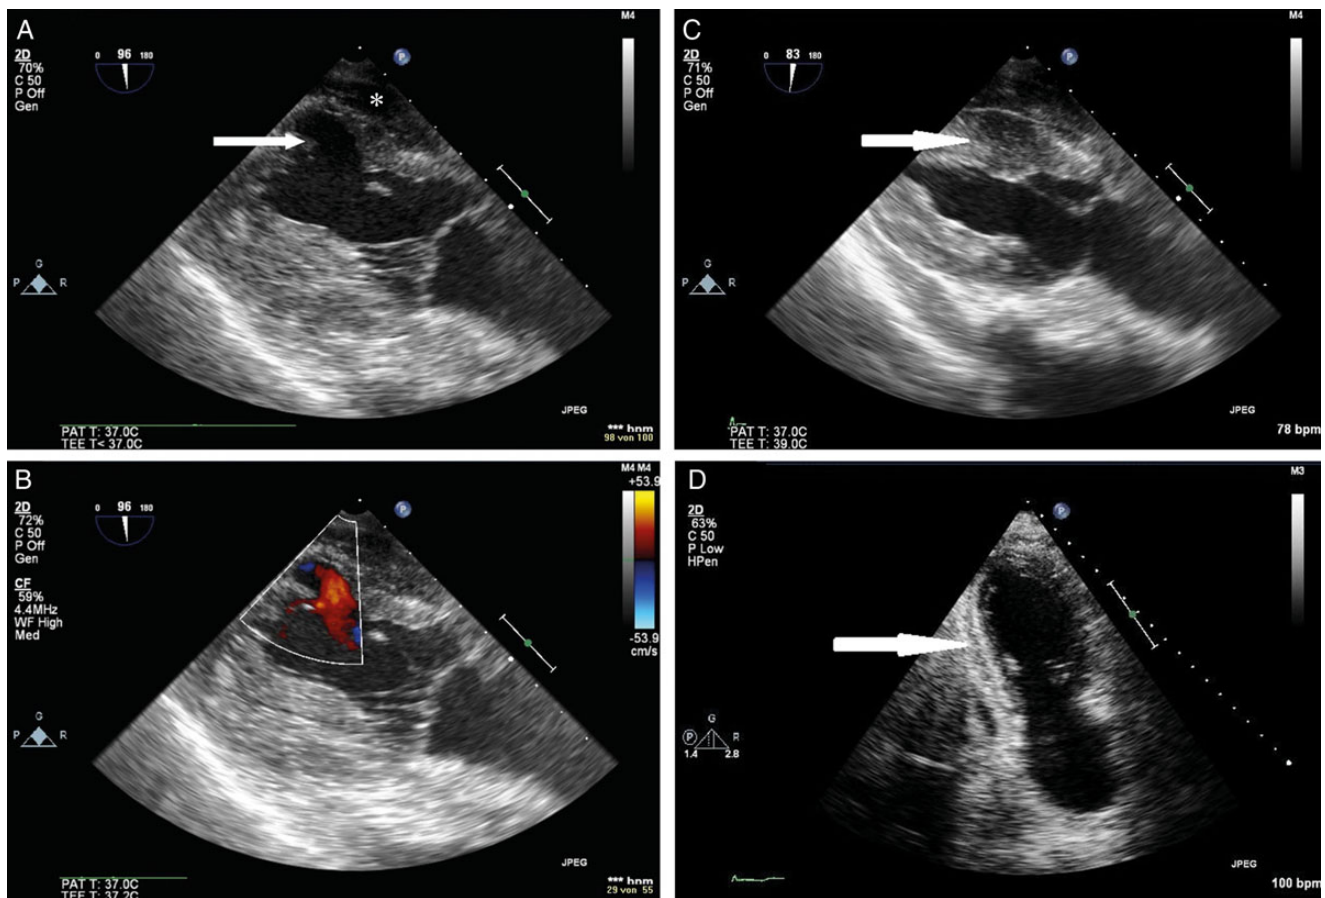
(A) Preoperative transoesophageal echocardiogram (transgastric long-axis view) showing an inferolateral left ventricular free wall rupture with a cavity created in the myocardium (white arrow) and an intrapericardial haematoma due to the lesion (asterisks). (B) Preoperative transoesophageal echocardiogram (transgastric long-axis view) with colour Doppler demonstrating the created rupture cavity in the myocardium washed by the blood stream. (C) Immediate postoperative transoesophageal echocardiogram (transgastric long-axis view) showing the inferolateral left ventricular free wall with the former myocardial cavity filled with GRF® glue and covered by epicardial CorMatrix ECM® patch (white arrow). (D) Three-month postoperative transthoracic echocardiogram (apical two-chamber view) showing the former inferolateral left ventricular free wall rupture with no more evidence of GRF® glue and epicardial CorMatrix ECM® patch. The hyperdense area is representing scarring/remodelling myocardial tissue (white arrow). GRF® glue: gelatine-resorcinol-formaldehyde glue; ECM: extracellular matrix.
